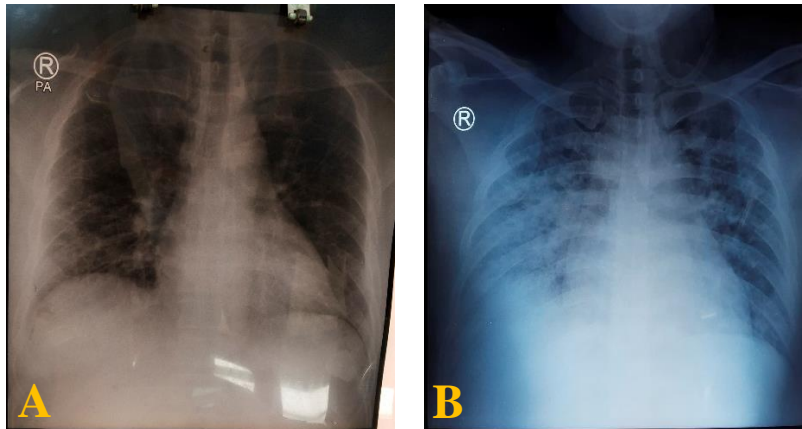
Chest X-Ray at Emergency ward (A) and third day of care (B).
